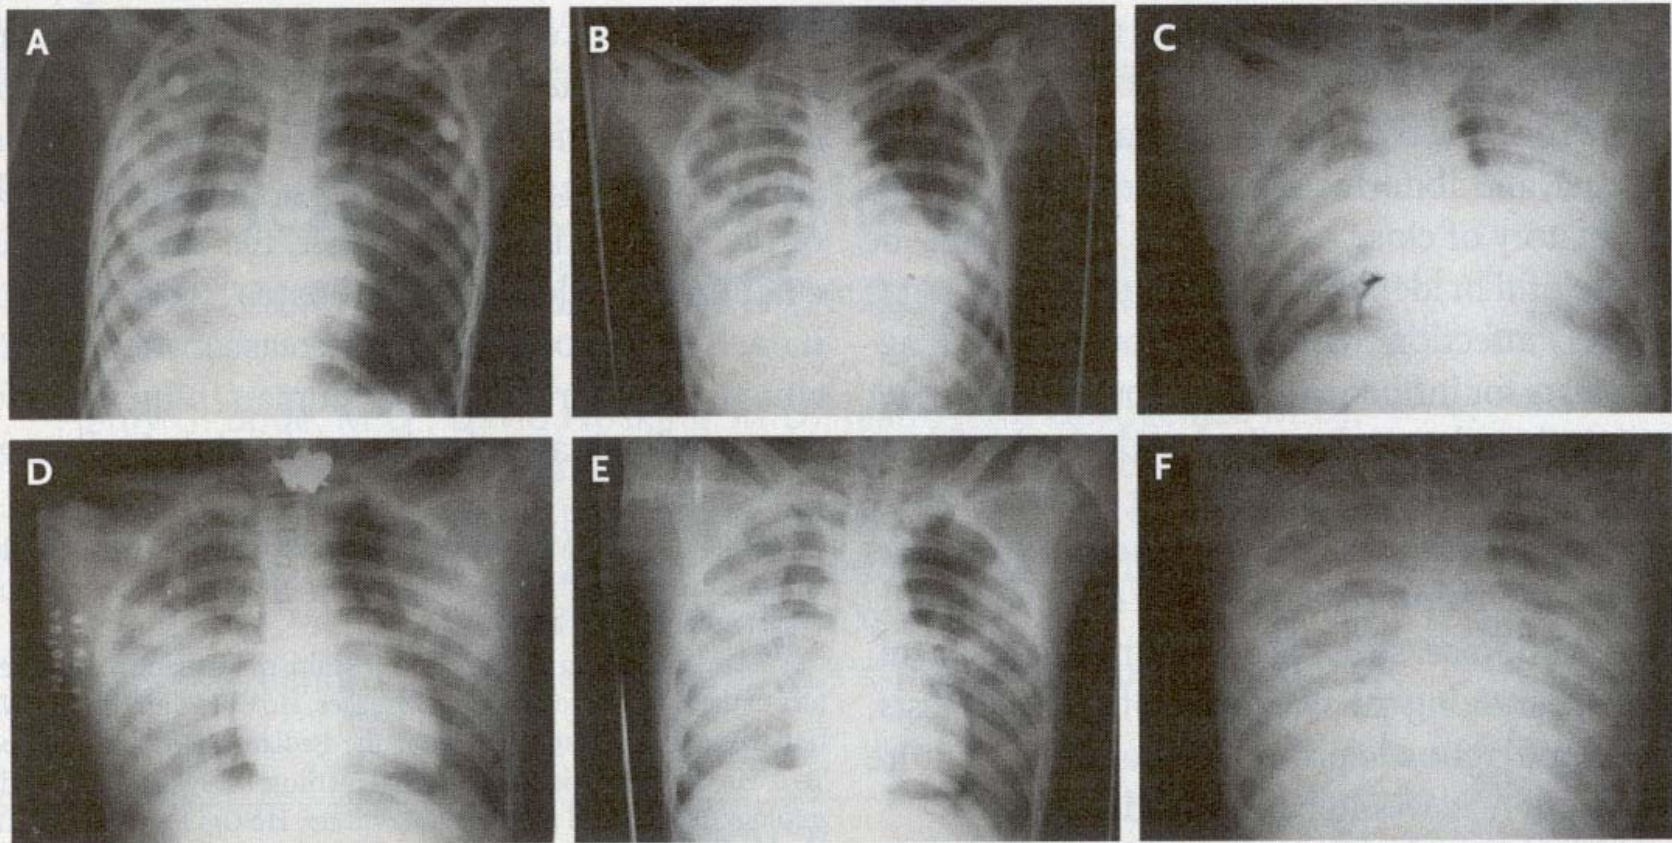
Chest Radiographs.
